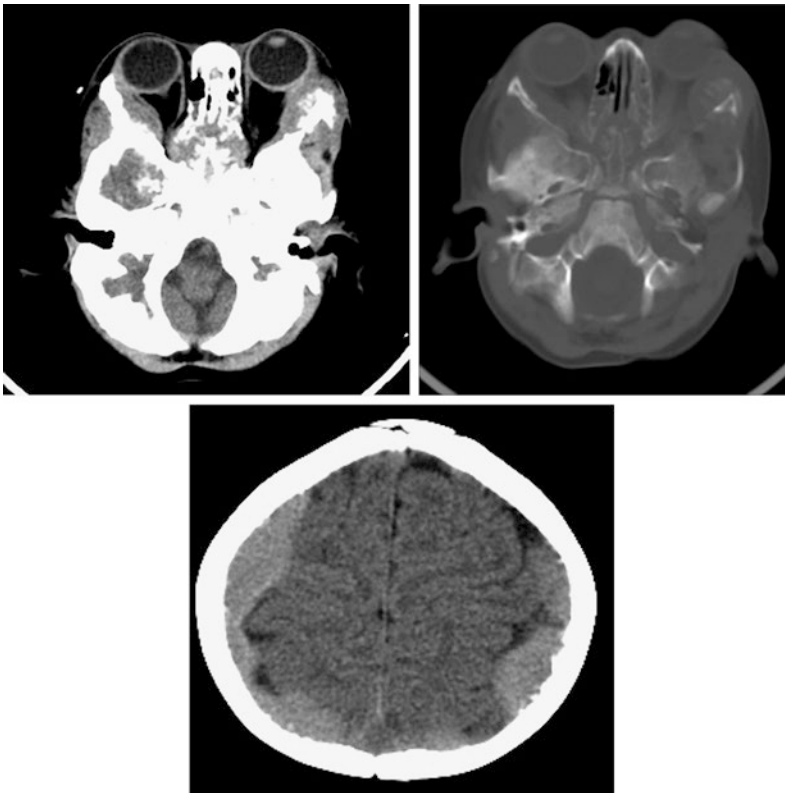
Orbital and calvarial metastatic neuroblastoma as first presentation of neuroblastoma in a 4 years old girl. Axial CT images in soft tissue (a) and bone window (b) showing bilateral slightly hyperdense soft-tissue masses along the lateral orbital wall with associated bony speculations. c Axial image at higher level demonstrates bilateral fronto-parietal extradural metastases
